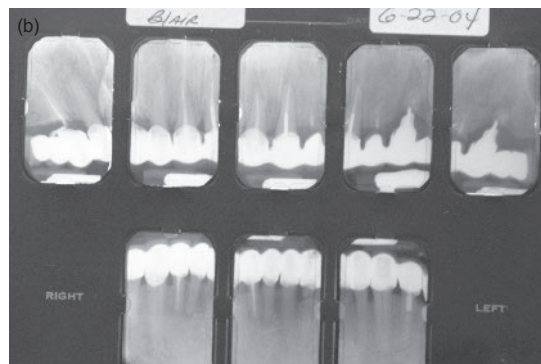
Periapical radiographs of the patient.
